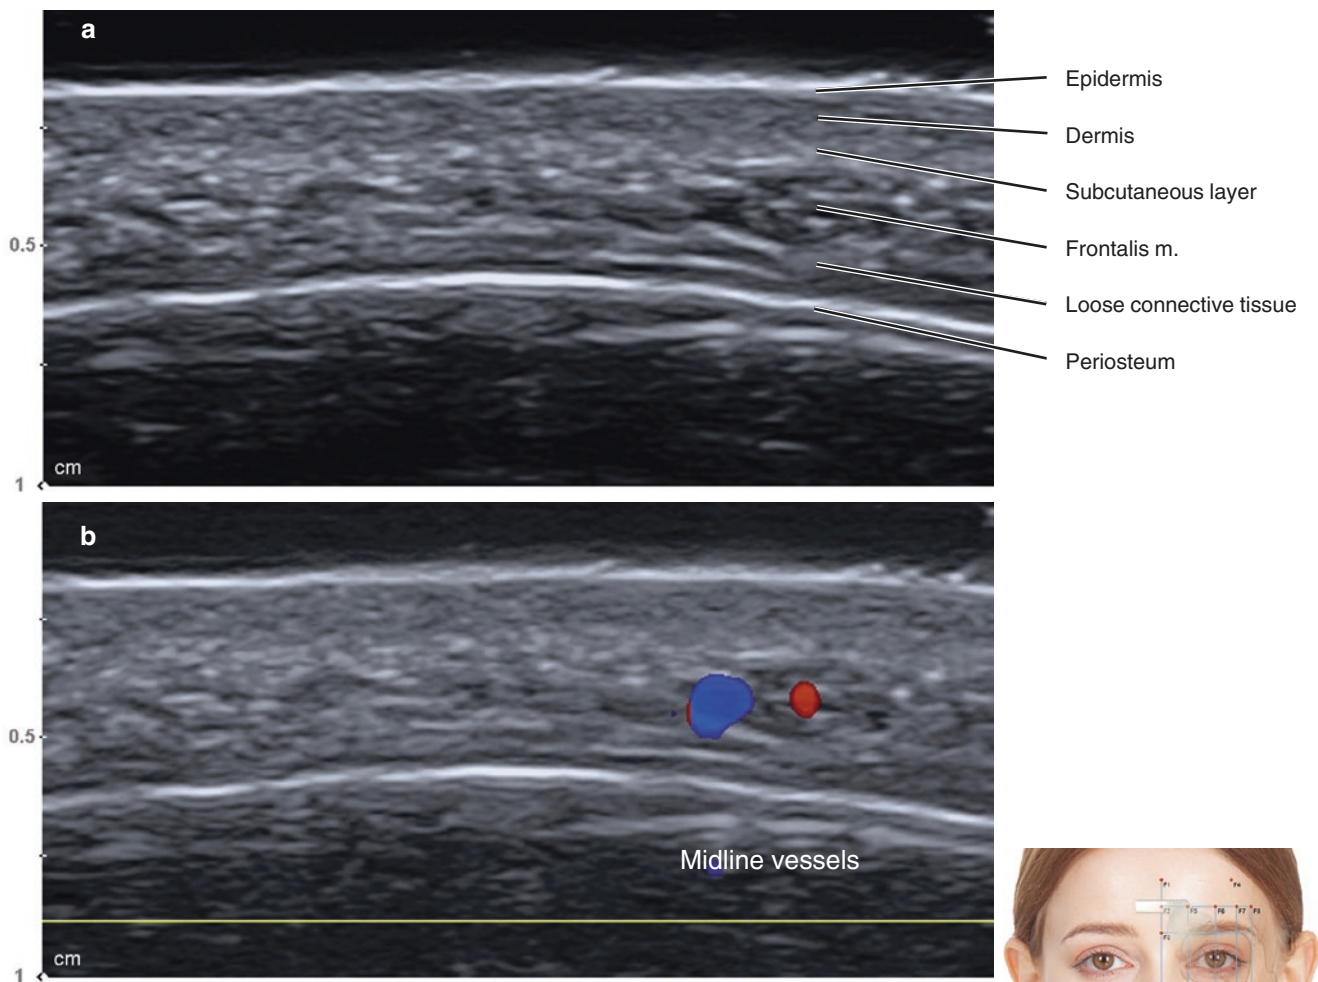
Ultrasonography on the midpoint between F1 and F3. (a) B mode (transverse view, 15 MHz by linear transducer) and (b) Doppler mode (transverse view, 15 MHz by linear transducer). (Published with kind permission of © Hee-Jin Kim 2020. All Rights Reserved)
